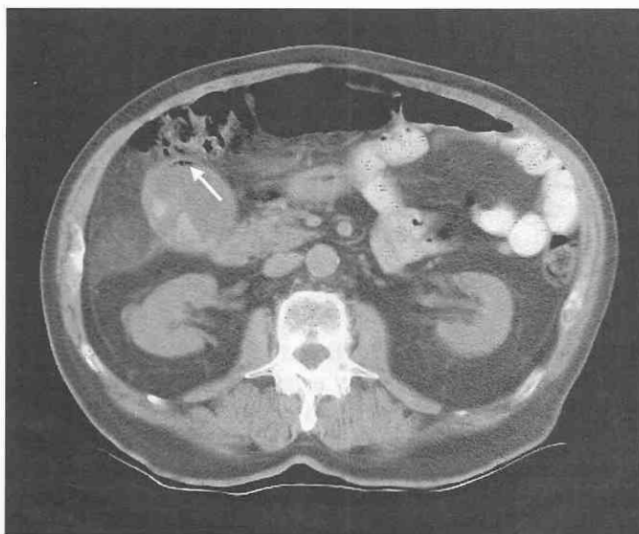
Gram-negative gas forming infection in gallbladder. CT scan shows enlarged gallbladder with thick wall, small amount of air (arrow), and faceted gallstones.
